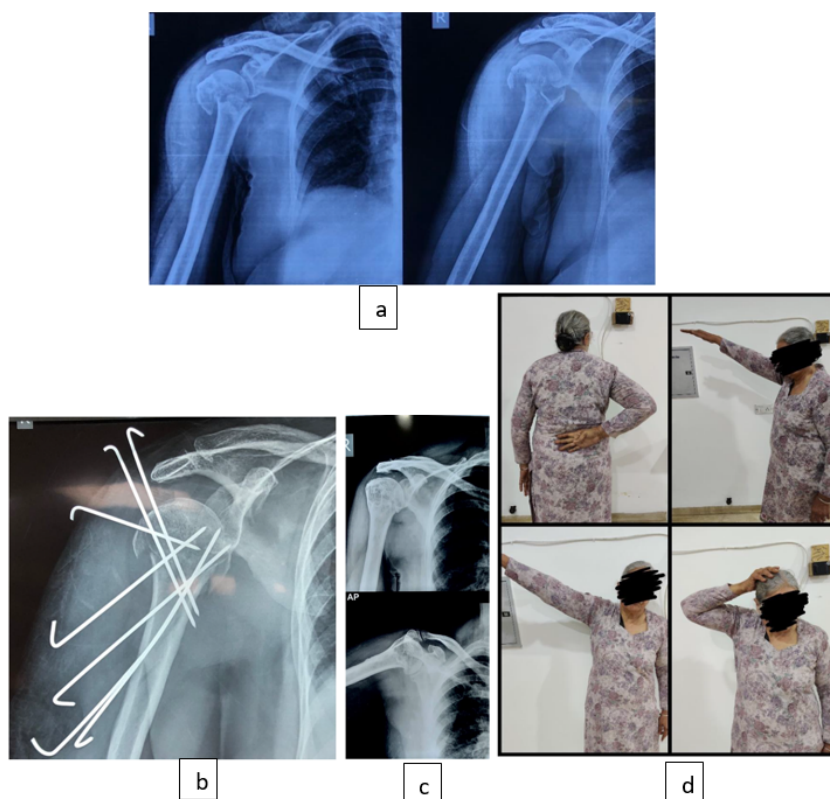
Patient 6 as per master chart- a): Preop X-ray; b): Post-op X-ray; c): Followup after 6 months; d): Clinical photographs
